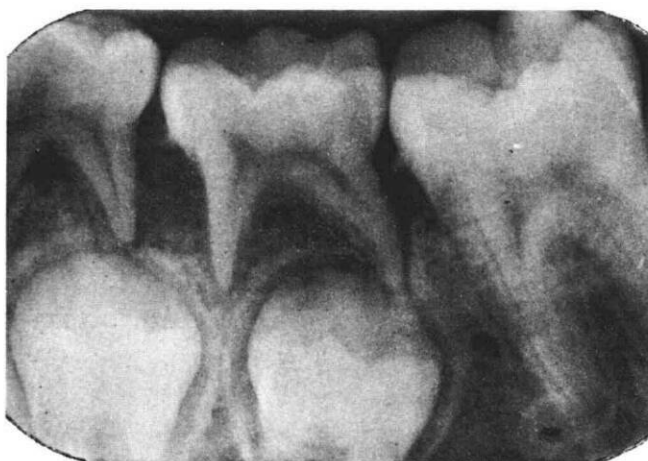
Radiographic features of JP in the primary dentition showing extensive alveolar bone loss with furcation involvement of primary molars.
